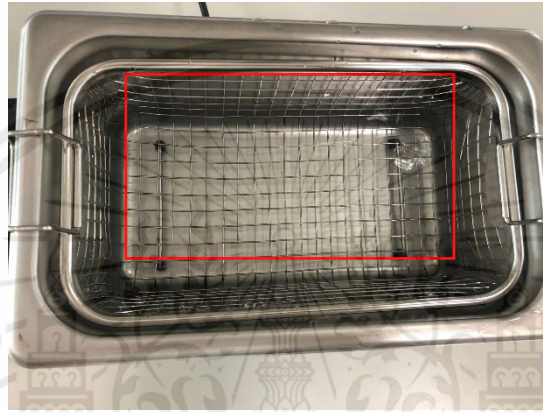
Cleaning the material by ultrasonic bath.
